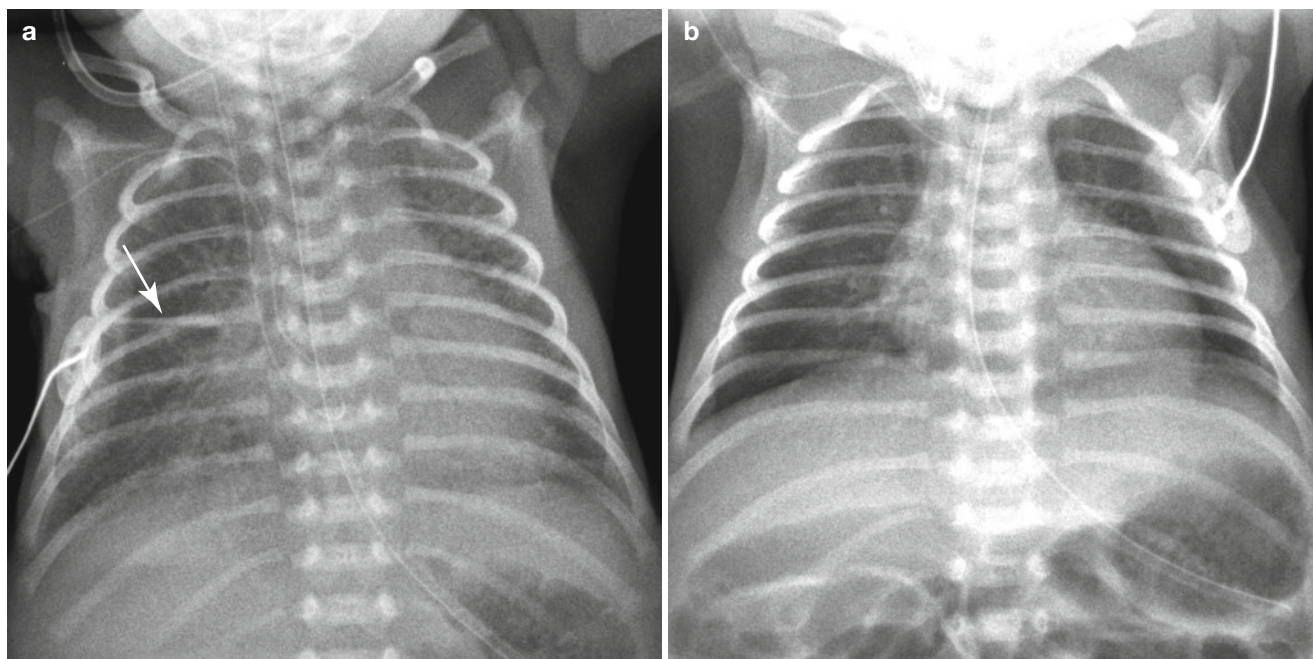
TTN in a 34-week-gestational-age newborn, delivered due to placental abruption. (a) Initial frontal chest radiograph demonstrates cardiomegaly and bilateral parahilar strandings. A small amount of fissural fluid is seen at the right minor fissure (*arrow*). There was mild
